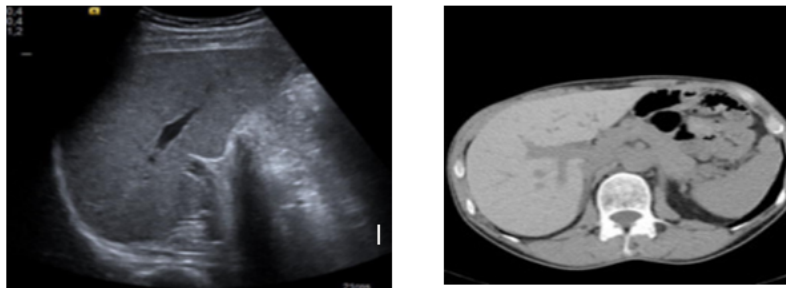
a) Liver Image-3D-US, b) Liver Image-3D-CT
